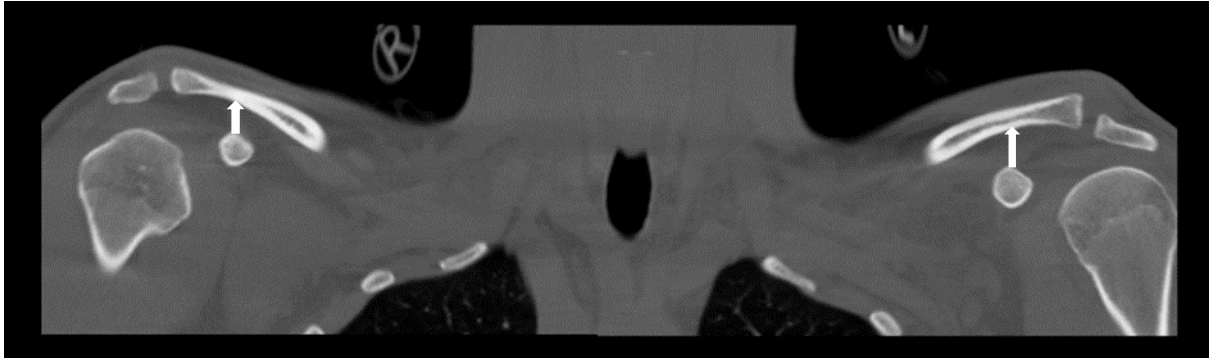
Antero-posterior CT scan of the upper part of thorax with AC joint dislocation on right side. CC-distance is marked by white arrows.
